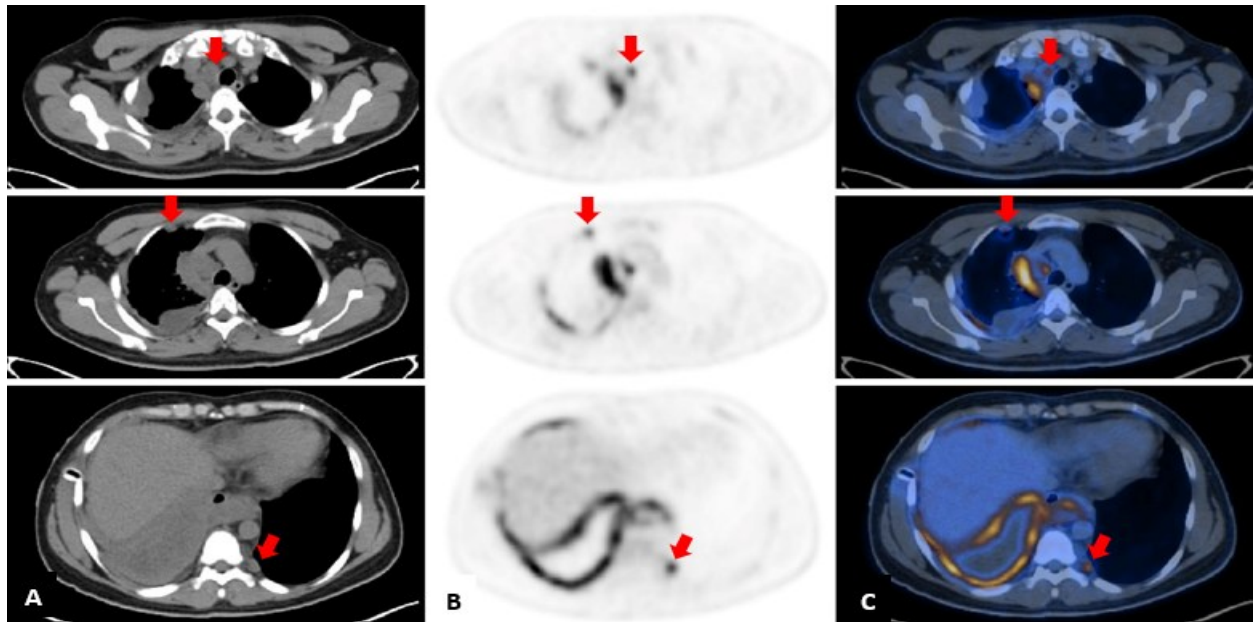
Axial view showing the (A) CT, (B) PET, and (C) fused PET/CT images of the patient's third whole-body PET/CT scan showing FDG-avid thoracic lymphadenopathies.
